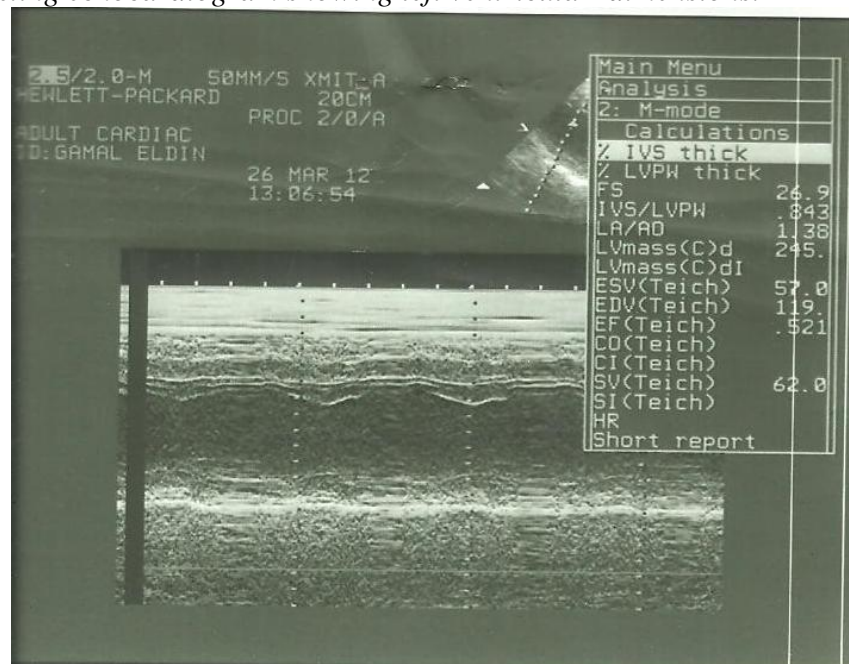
showing the same patient with echocardiographic LVH(L.V mass 245 g and L.V mass index=141 g/m²)
